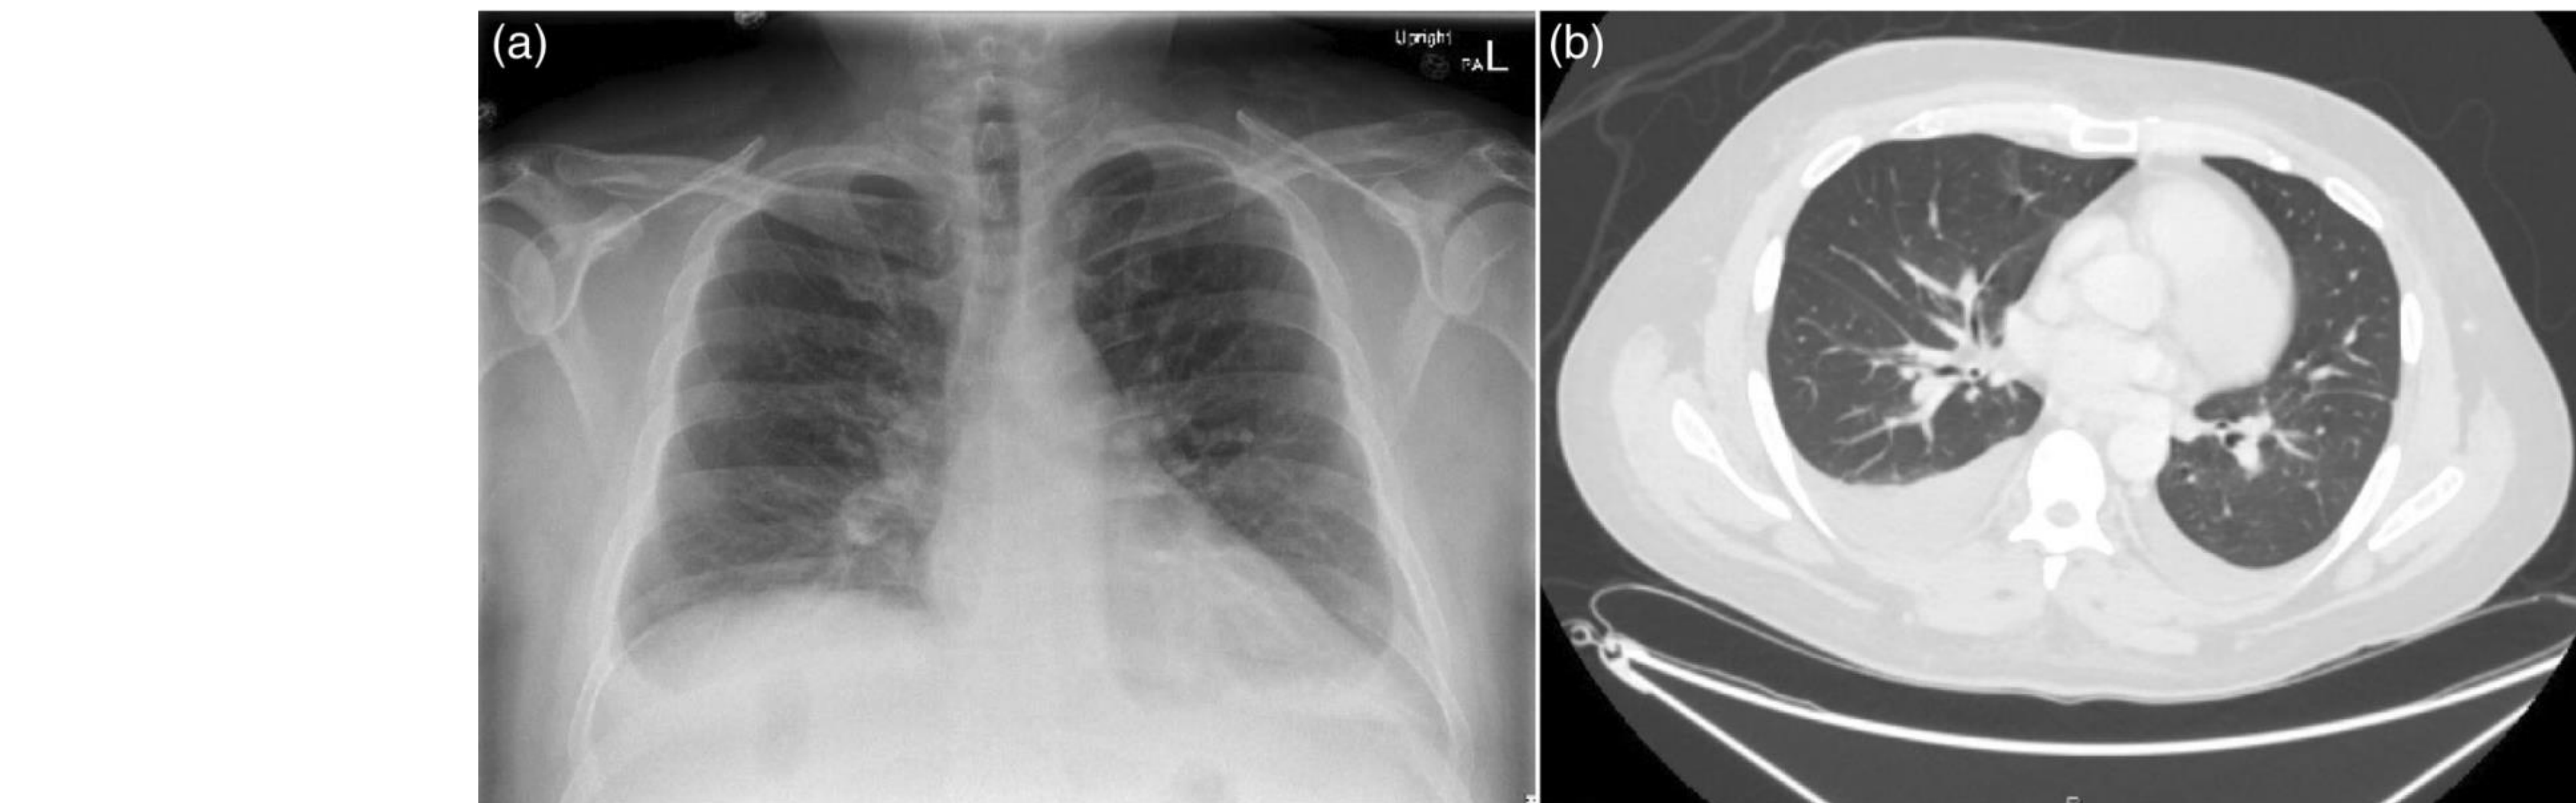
Chest x-ray (a) and computerized tomography (b) on presentation showed small effusions and underlying atelectasis at the lung bases. The cardio-mediastinal silhouette is normal.
